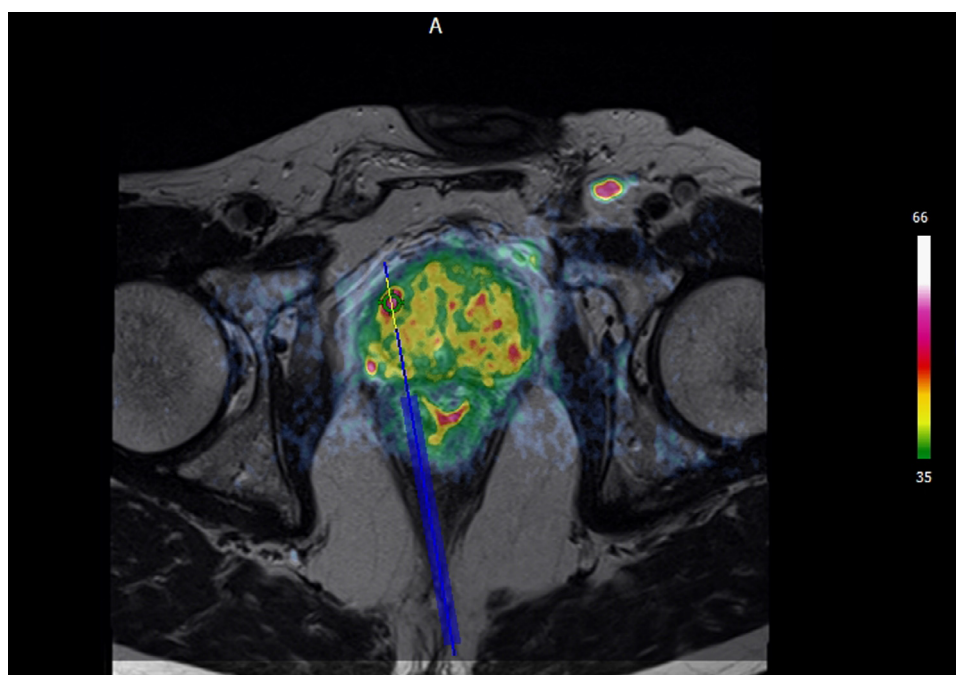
T2 weighted intraprocedural MRI with diffusion weighted imaging overlay shows the target lesion. This can be helpful for target lesions best seen on diffusion. Of note, this patient also had a left inguinal lymph node which was enlarged and seen to have restricted diffusion. (Color version of figure is available online.)
